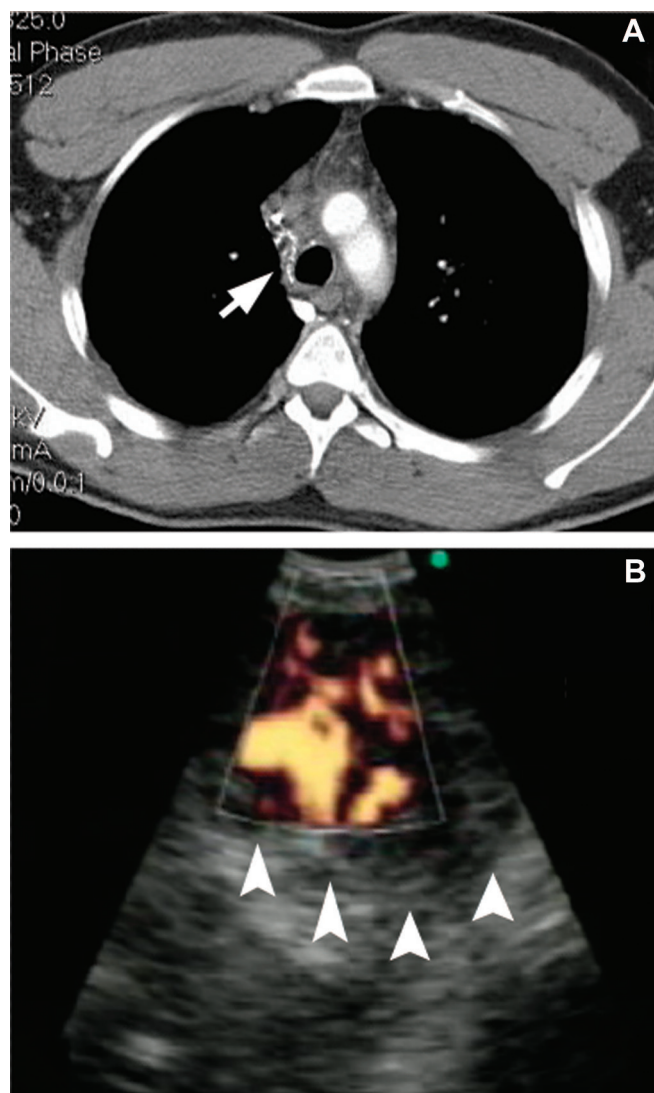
A, Axial contrast-enhanced computed tomography chest image from patient with clinical superior vena cava (SVC) obstruction demonstrating prominent right paratracheal lymphadenopathy causing significant narrowing of the SVC. Large collateral vessels in the right paratracheal region may be seen posterior to the narrowed SVC (arrow). B, Endobronchial ultrasound image of right paratracheal region of patient in (A). Doppler mode demonstrates large vessels within a poorly defined lymph node mass (arrowheads).
